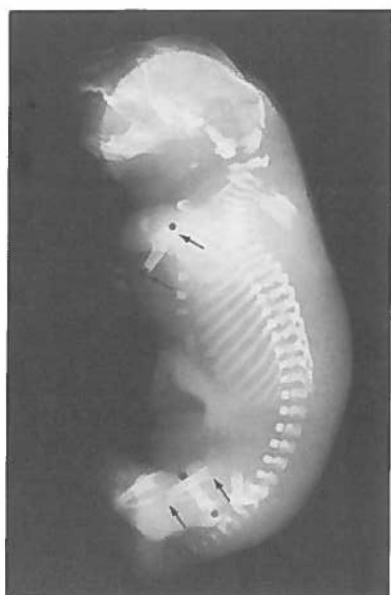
Radiograph of a control fetus. Arrows indicate to calcified portion of the humerus and femur used for assessment of skeletal development.
